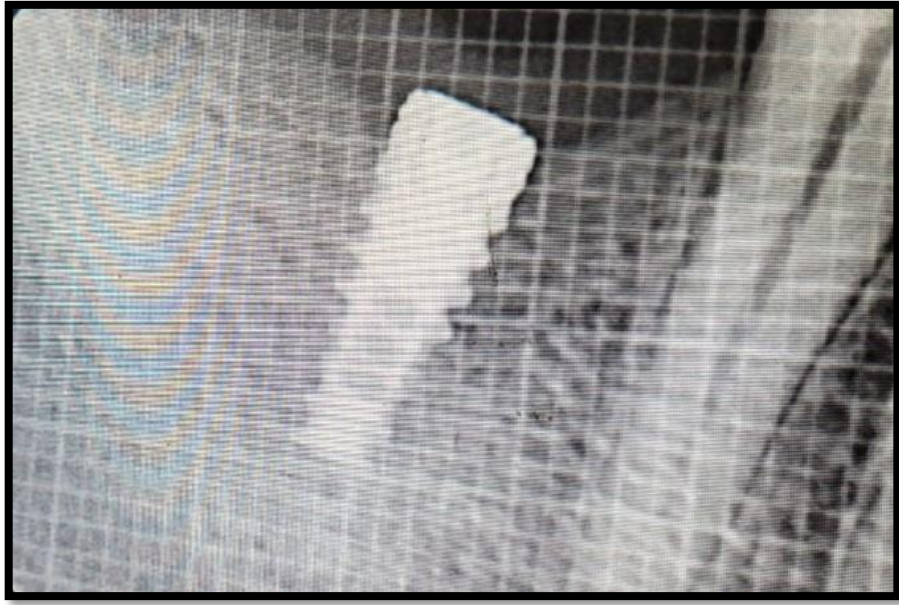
Radiograph at one month
